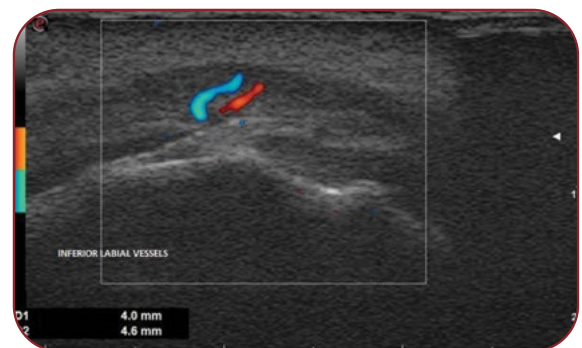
Ultrasonographic measurement of the depth of the inferior labial vessels at the half of the distance between the midline and the modiolus
